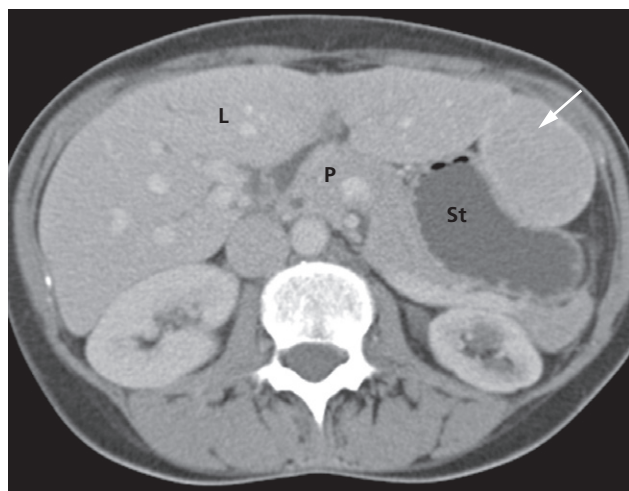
Gastrointestinal stromal tumour on CT. There is a smooth ovoid mass arising from the anterior wall of the stomach (arrow). This causes an indentation of the stomach. L, liver; P, pancreas; St, stomach.
